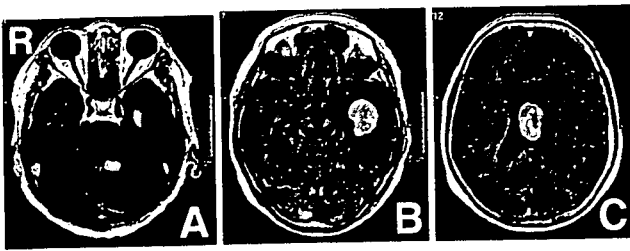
T₁-weighted magnetic resonance images with contrast medium showing a diffusely enhanced lesion in the left temporal horn of the lateral ventricle (B), septum pellucidum (C), and periventricular area of the fourth ventricle (A).
